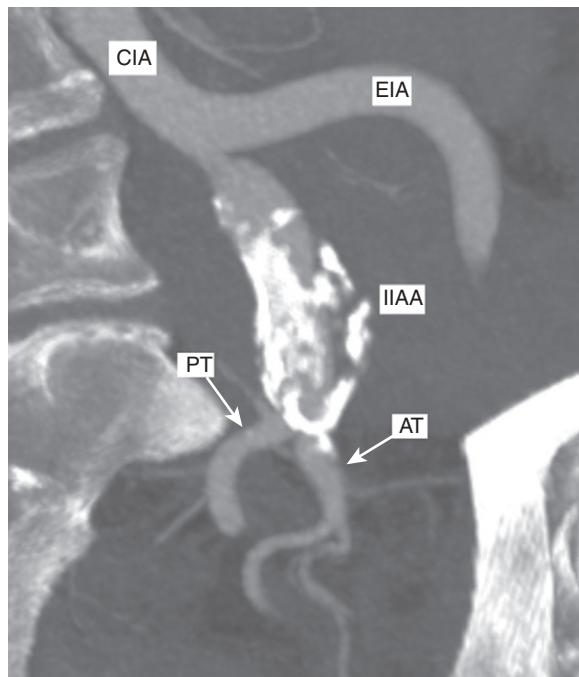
CT scan of a left isolated IIAA involving the anterior and posterior trunks. *AT*, anterior trunk (inferior gluteal artery, internal pudendal artery, medial rectal artery, obturator artery, superior and inferior vesical arteries); *CIA*, common iliac artery; *EIA*, external iliac artery; *IIAA*, internal iliac artery aneurysm; *PT*, posterior trunk (superior gluteal artery, lateral sacral arteries). (With permission from Garrido Espeja A, Andrés Navarro O, Roche Rebollo E, et al. Exclusively intrahypogastric sandwich technique to treat an isolated internal iliac artery aneurysm. *J Vasc Interv Radiol.* 2020;31(3):516–519.)
